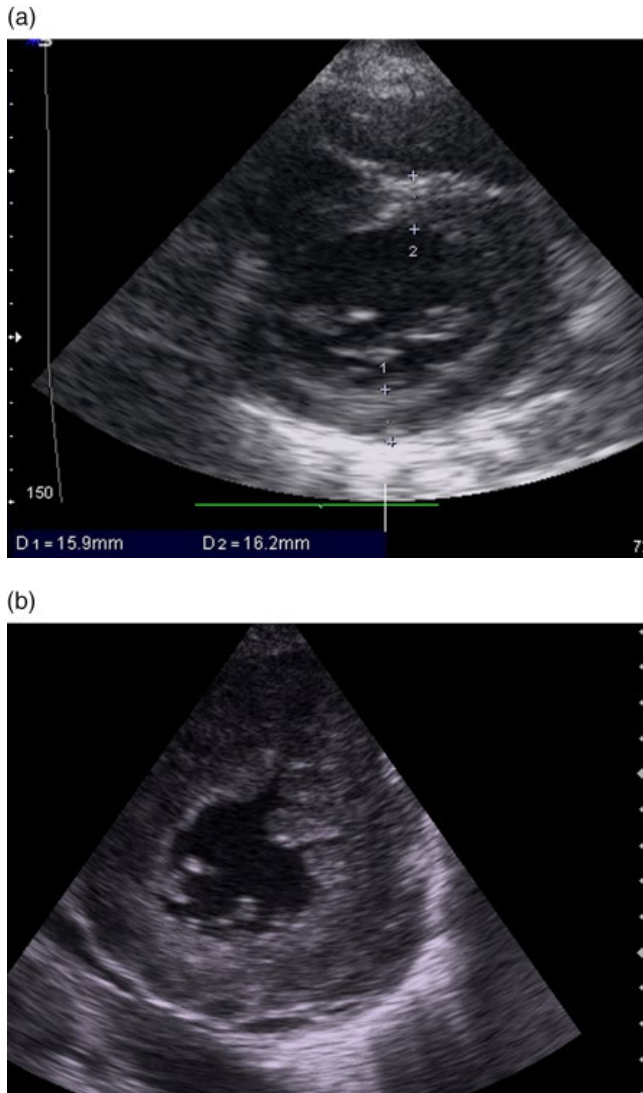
(a,b) Parasternal short-axis views of severely hypertrophied ventricles in diastole. While calliper measurements have not been made in panel (b), the 1 cm hash-marks on the right of the image demonstrate an increased wall thickness of about 30 mm and a severely diminished end-diastolic diameter of about the same. A small pericardial effusion is present in panel (b).
